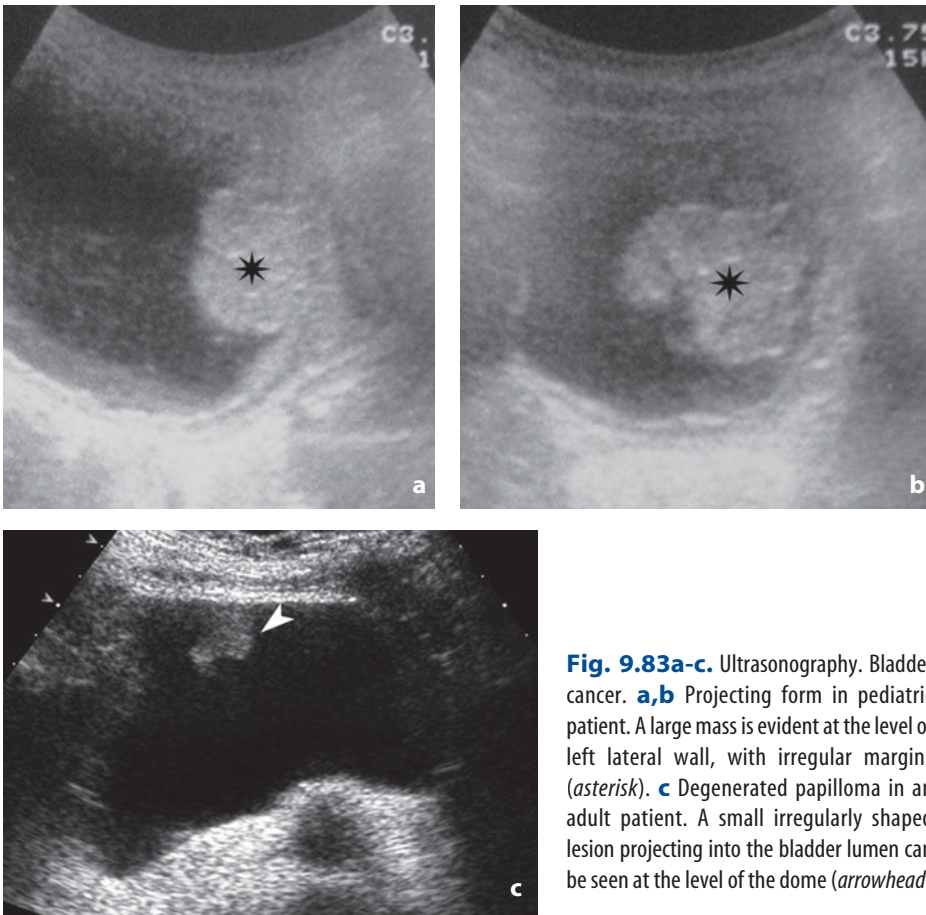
Ultrasonography. Bladder cancer. a,b Projecting form in pediatric patient. A large mass is evident at the level of left lateral wall, with irregular margins (*asterisk*). c Degenerated papilloma in an adult patient. A small irregularly shaped lesion projecting into the bladder lumen can be seen at the level of the dome (*arrowhead*)
